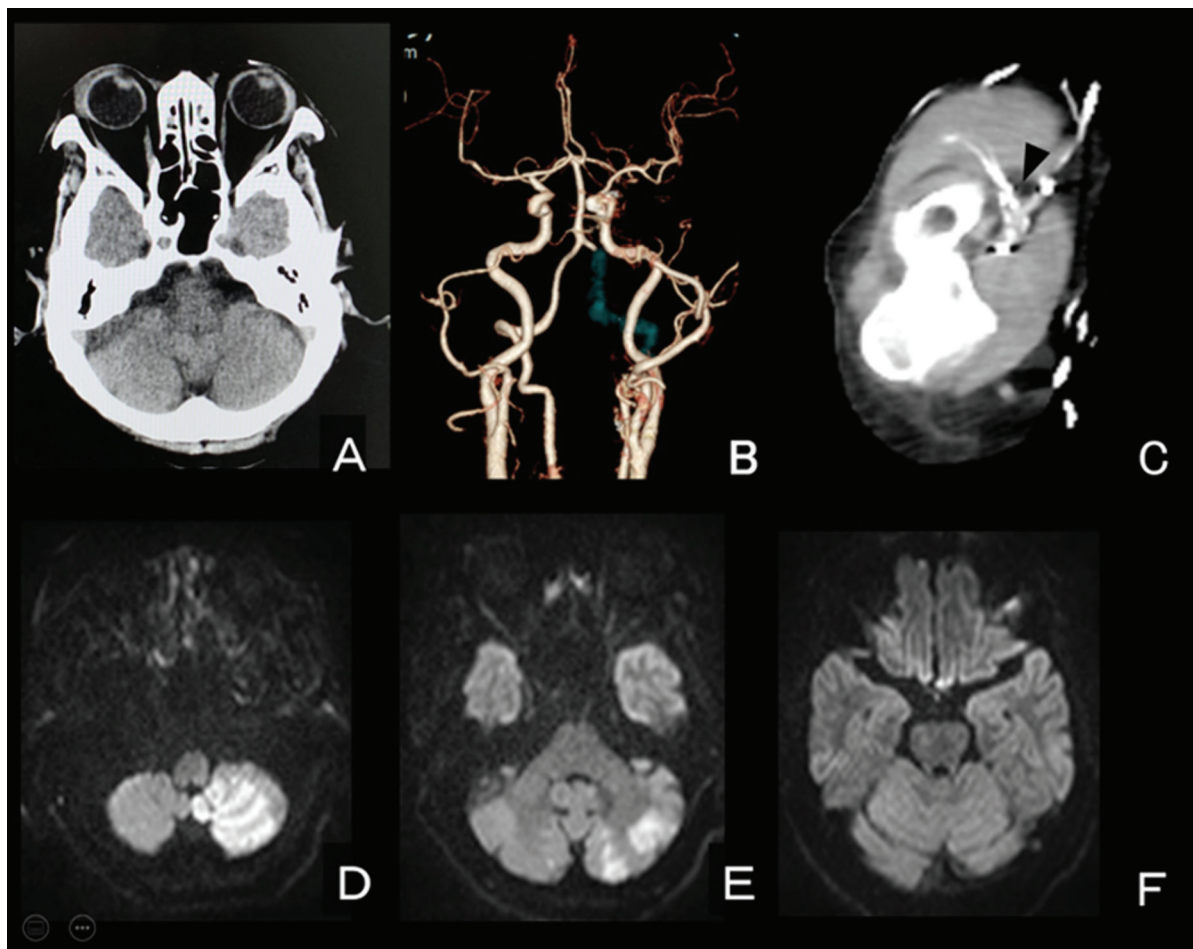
Preoperative imaging findings: (A) CT and (B) contrast-enhanced CT revealed left vertebral artery occlusion and no cerebral hemorrhage. (C) Contrast-enhanced CT of the left arm revealed acute occlusion of the left radial artery (▼). (D–F) Diffusion-weighted MRI showed high-signal areas, suggesting acute cerebral infarction of the left lateral medulla oblongata and the left cerebellar hemisphere. CT: computed tomography; MRI: magnetic resonance imaging
